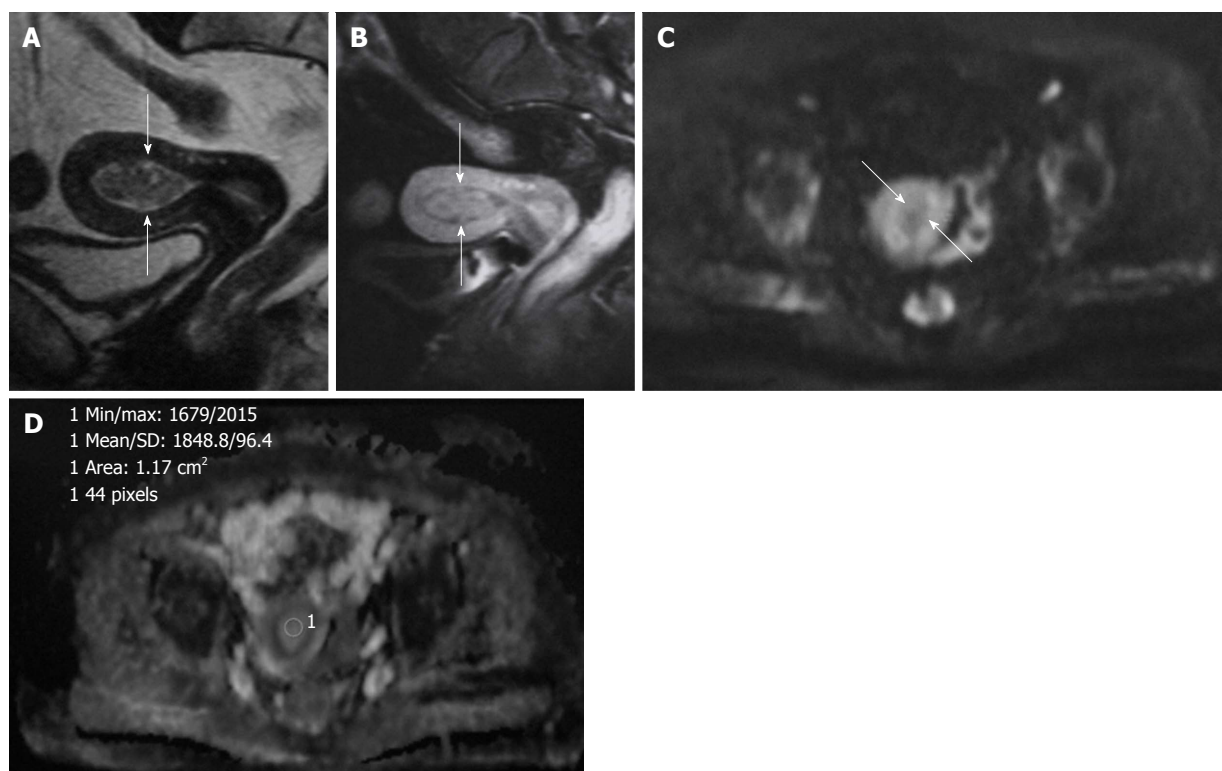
A 42-year-old woman with endometrial polyp. A: Hypointense polyp in the endometrial cavity on sagittal T2-weighted image mimicking low grade endometrial carcinoma (arrows); B: Sagittal contrast-enhanced T1-weighted image with fat suppression shows enhancing endometrial polyp (arrows); C: On the axial DWI ($b = 1000 \text{ s/mm}^2$) image, the mass is hypointense clearly excluding malignancy (arrows); D: Corresponding axial apparent diffusion coefficient (ADC) map. The ADC value within the mass is $1.85 \times 10^{-3} \text{ mm}^2/\text{s}$.
